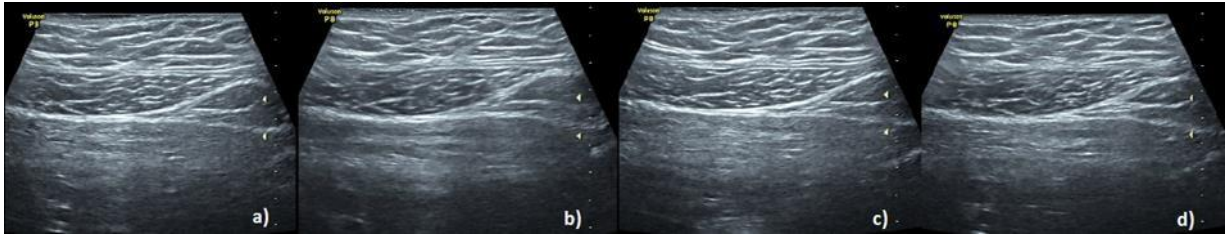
Ultrasound images of RAM. Researchers' archive, 2018.
